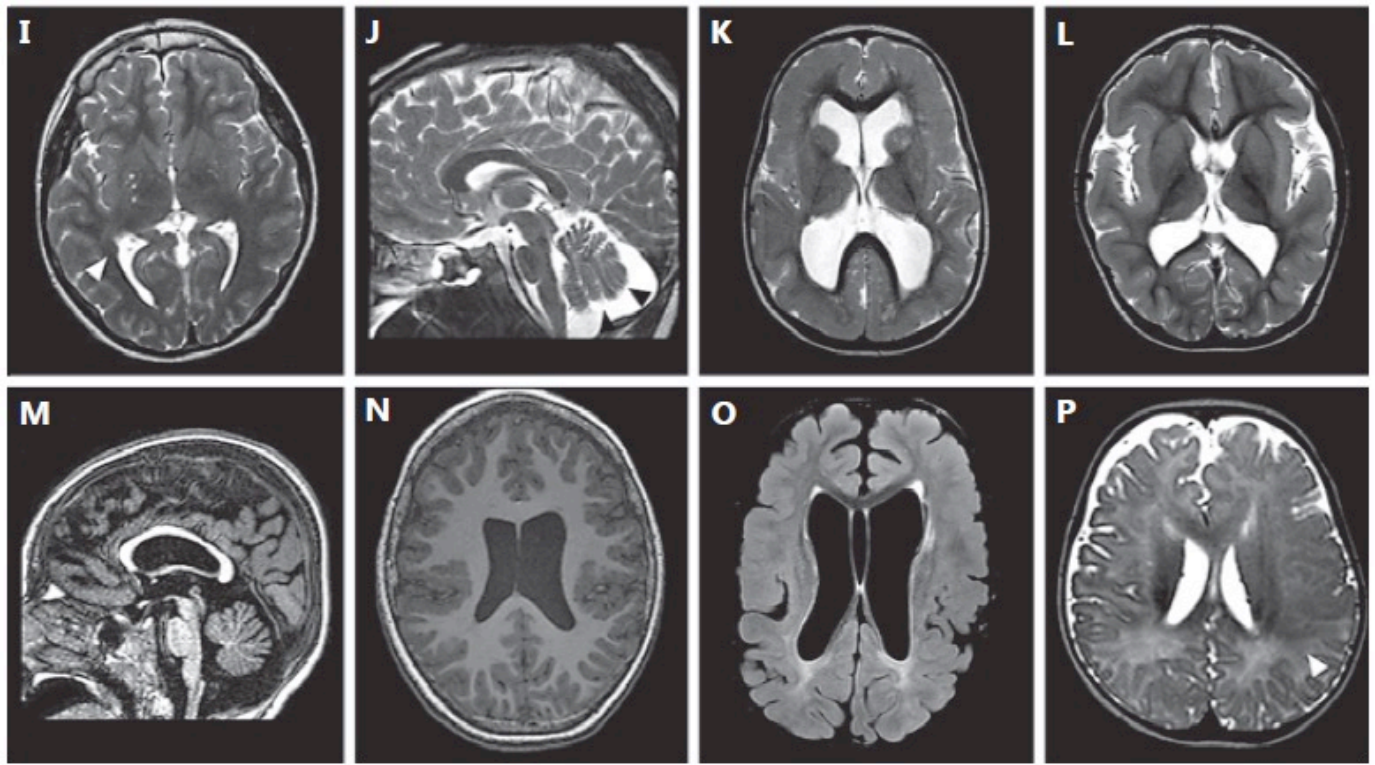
Brain MRI of patients with different malformations of the cerebral cortex. A T1-weighted axial section. Posterior to anterior pachygyria in a boy with LIS1 mutation. B T2-weighted axial section. Diffuse SBH in a girl with DCX mutation. C, D T2-weighted axial section and T1-weighted sagittal section. Lissencephaly and cerebellar hypoplasia in a girl with RELN mutation. E, F T1-weighted axial section and T1-weighted sagittal section. Thickened cortex with simplified gyral pattern and cerebellar hypoplasia in a girl with TUBA1A mutation. G T1-weighted axial section. Diffuse simplified gyral pattern with prominent thickening and infolding of the sylvian fissures in a boy with TUBB2B mutation. H T1-weighted axial section. Typical, classical bilateral PNH in a girl with an FLNA mutation. Bilateral nodules of subependymal heterotopia are contiguous and rather symmetric, extensively lining the ventricular walls.
